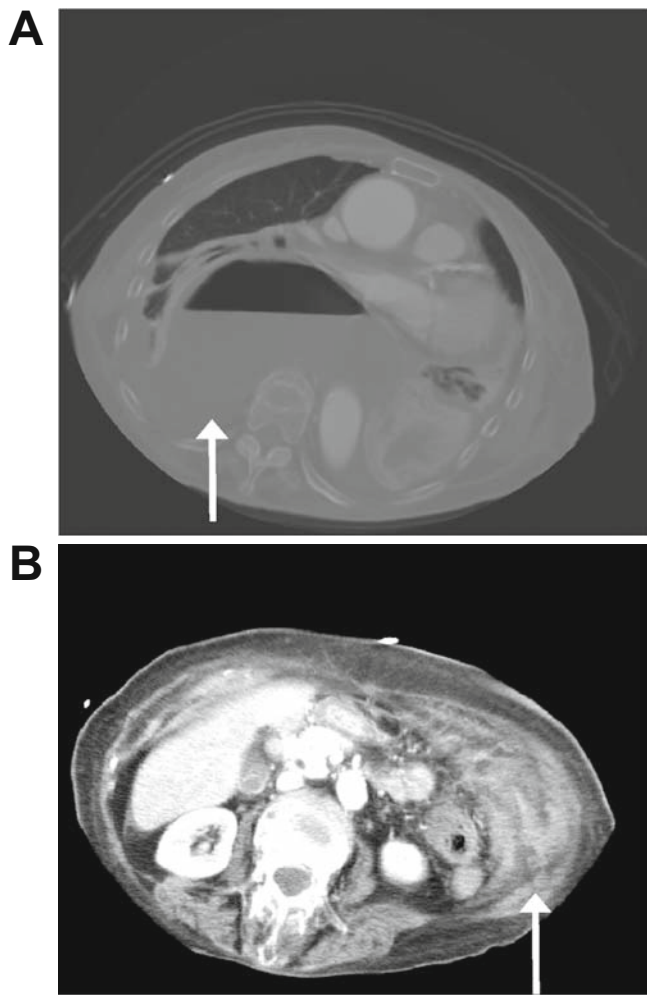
Computed tomography (CT) images of A chest and B abdomen. A Chest CT showed aberration of the stomach body in the posterior mediastinum (*arrow*). B Abdominal CT showed increased fat tissue density, indicative of peritonitis (*arrow*)
